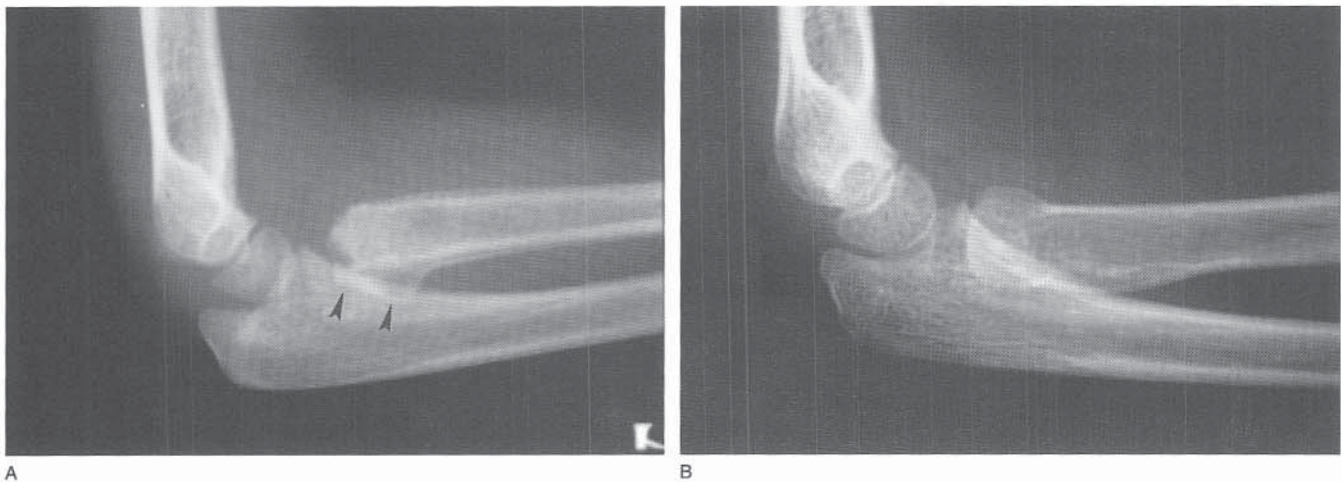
A, Lateral radiograph of the elbow of a 7-year-old girl 4 weeks after injury. The radial neck fracture is angulated 80 degrees (*arrowheads*). There is significant healing, as evidenced by calcification within the intact periosteal sleeve. The patient was treated with observation. B, Lateral radiographs obtained 1 year after injury showing significant remodeling.
